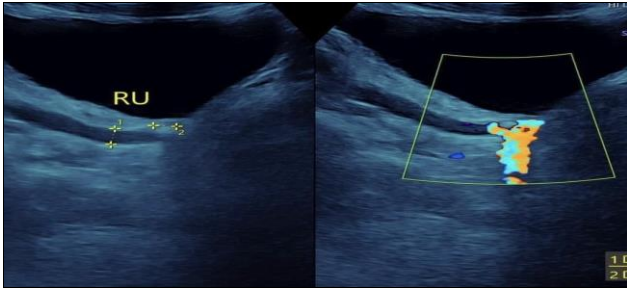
A 31-year-old man's right iliac fossa pain was diagnosed on sonography, which revealed a stone impinged in the right vesico-ureteric junction (VUJ).
